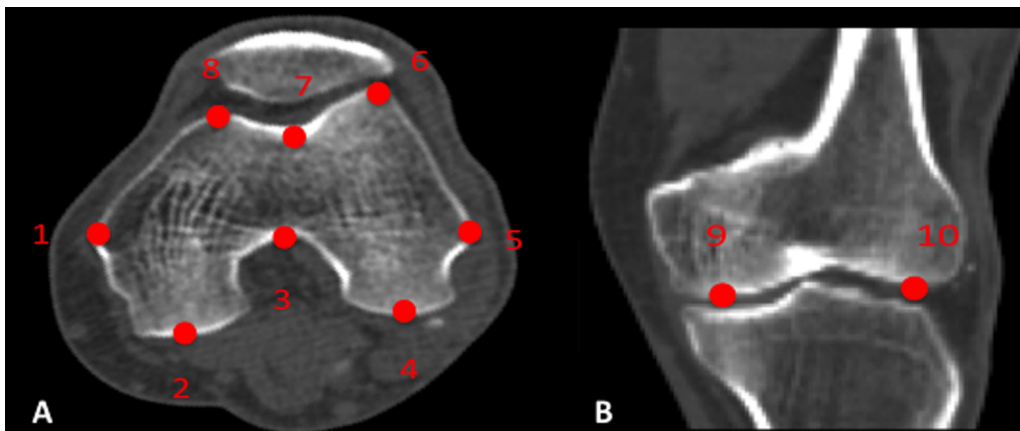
Location of landmarks on axial (A) and frontal (B) CT scan slices: (1) medial epicondyle, (2) most dorsal point on medial condyle, (3) top of intercondylar notch, (4) most dorsal point on lateral condyle, (5) lateral epicondyle, (6) most ventral point on lateral edge of trochlear groove, (7) most distal point at bottom of the trochlear groove, (8) most ventral point on the medial edge of the trochlear groove, (9) most distal point on medial condyle, (10) most distal point on lateral condyle.
